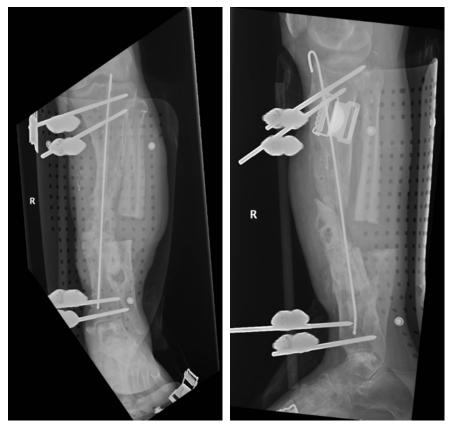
Ap and Lateral Xrays after excision of his infected bony tissue, removal of broken hardware, restoration of alignment and rotation, provisional fixation in the form of an antibiotic nail and external fixator, and free flap reconstruction.
